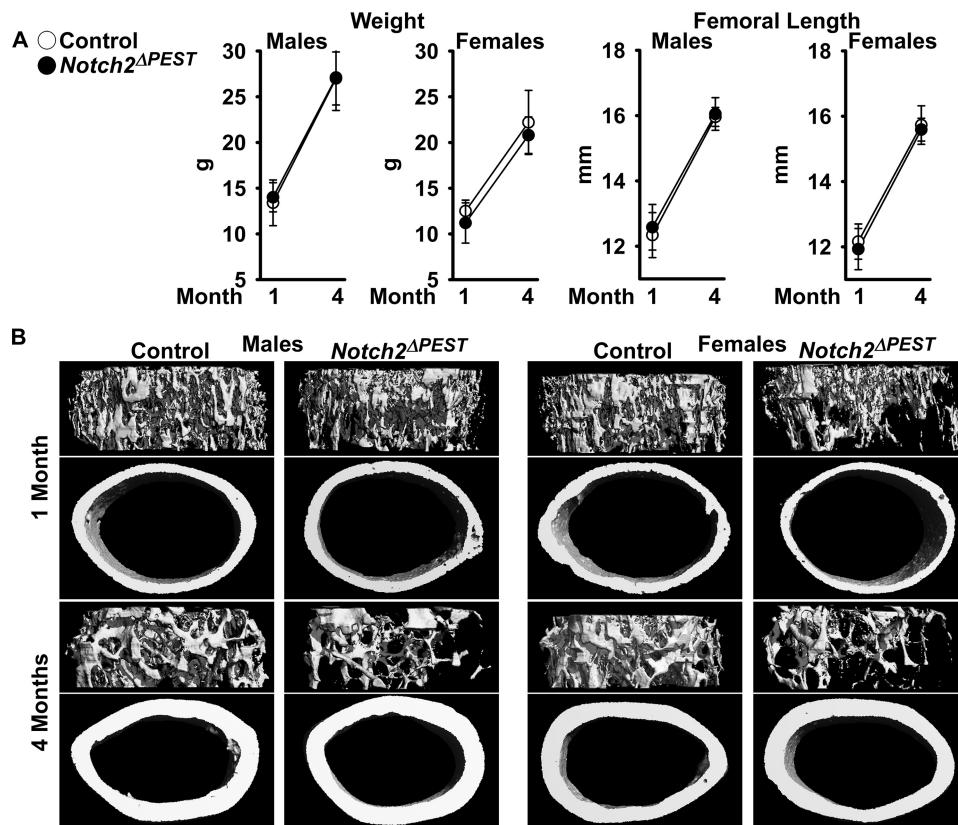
Notch2* activation in osteoblasts causes osteopenia. One- and 4-month-old male and female *BGLAP-Cre;Notch2*^{ΔPEST/ΔPEST} (black dots; *Notch2*^{ΔPEST}) were compared with sex-matched littermate *Notch2*^{COIN/COIN} controls (open circles). *A*, weight and femoral length. Values are means ± S.D.; in males at 1 month of age *n* = 7 for control, *n* = 12 for *Notch2*^{ΔPEST}, and at 4 months of age *n* = 6 for control, *n* = 6 for *Notch2*^{ΔPEST}; in females at 1 month of age *n* = 7 for control, *n* = 7 for *Notch2*^{ΔPEST}, and at 4 months of age *n* = 5 for control, *n* = 6 for *Notch2*^{ΔPEST}, all biological replicates. *B*, representative μ CT images of femoral proximal trabecular bone and midshaft. Complete data set in Table 4.
